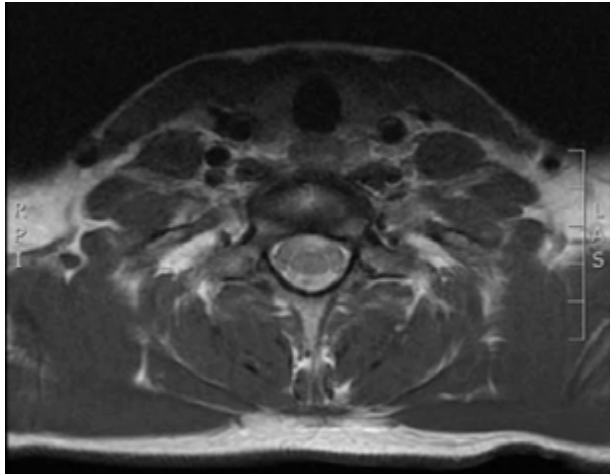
Contrast magnetic resonance imaging (MRI) of the cervical spine (axial plane) that shows spinal cord injury involving anterior horns with abnormal contrast uptake and contrast uptake of the roots, mainly anterior C5, C6, C7 and C8. Source: Document obtained during the study.
